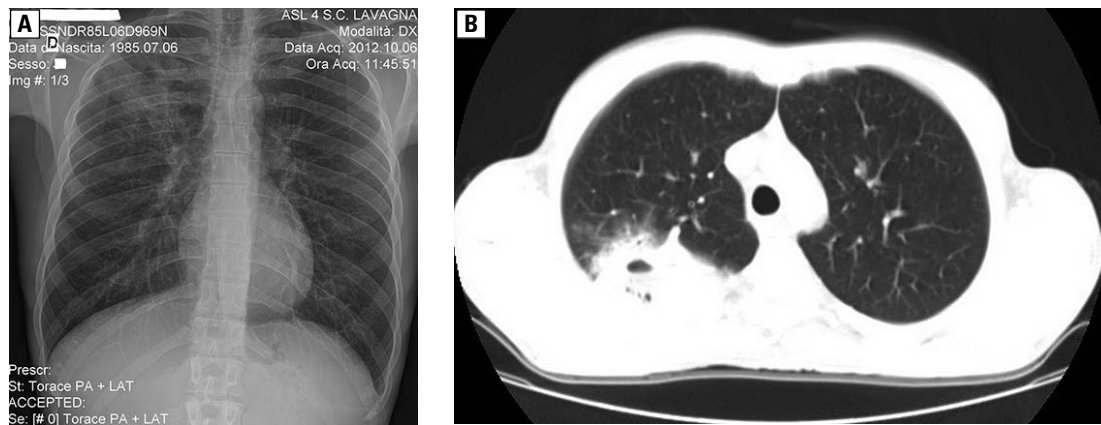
A — chest radiograph shows a right upper cavitation; B — chest computed tomography: cavitory pulmonary lesion (10.7×7.9 cm) at the level of the dorsal segment of the right upper pulmonary lobe
